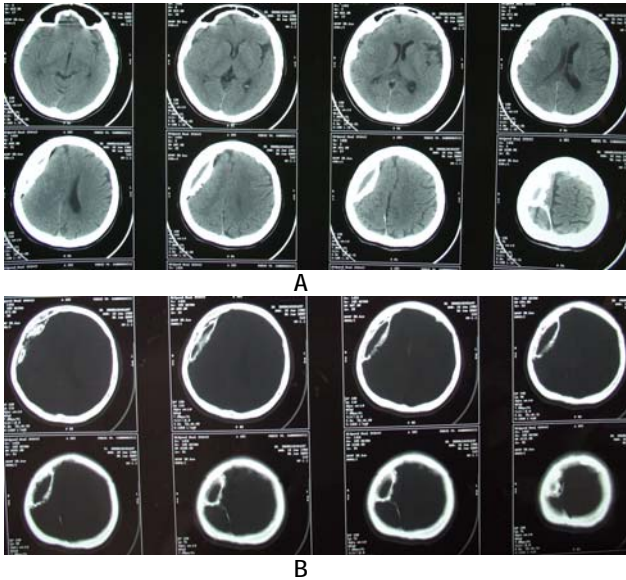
1B Preoperative brain CT-scan (native and bone windows)
